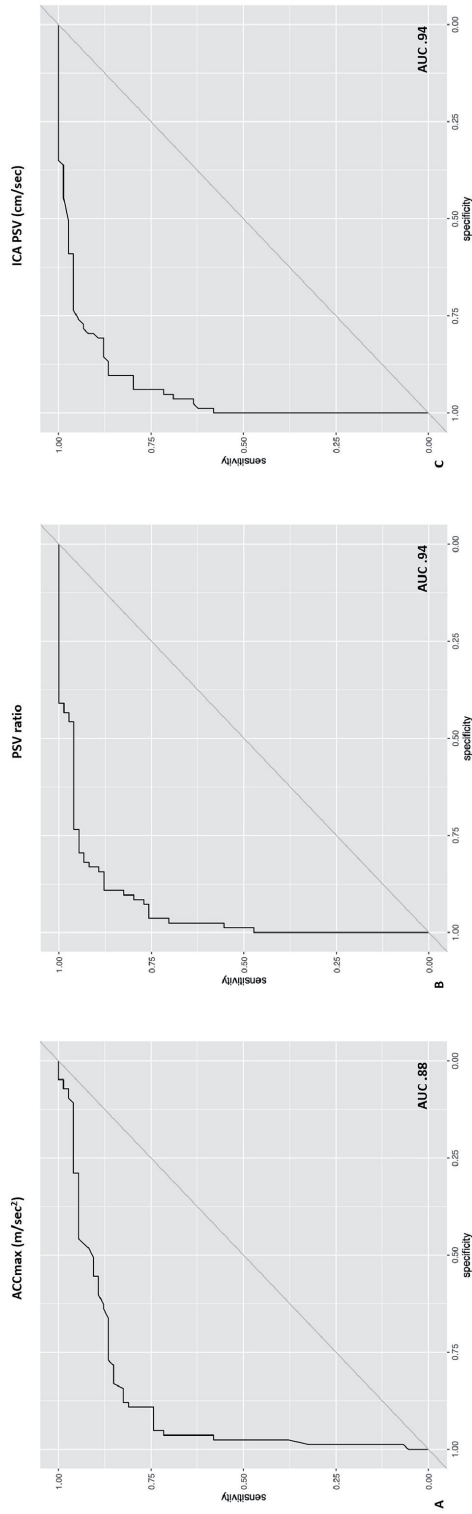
ROC-curves for ACCmax, PSV ratio and ICA PSV for diagnosing  $\geq 50\%$  ICA stenosis. Data of 157 carotid arteries were used for determining the ROC-curves for ACCmax (A), PSV ratio (B) and ICA PSV (C) to diagnose  $\geq 50\%$  carotid stenosis (based on CTA-imaging). The area under the curve (AUC) is given in the figure. ACCmax: maximal systolic acceleration, PSV ratio: peak systolic velocity ratio, ICA PSV: internal carotid artery peak systolic velocity.
